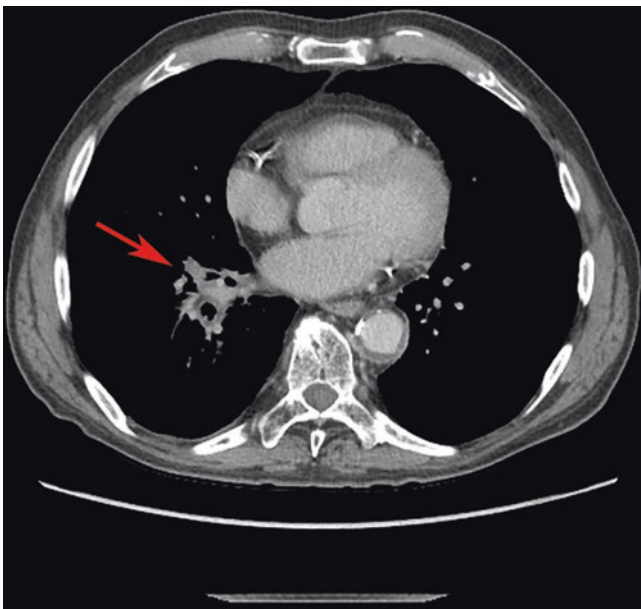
Computed tomography scan of a patient with tracheobronchial amyloidosis shows narrowing of the central bronchial tree (arrow) in the right hilar/perihilar area
